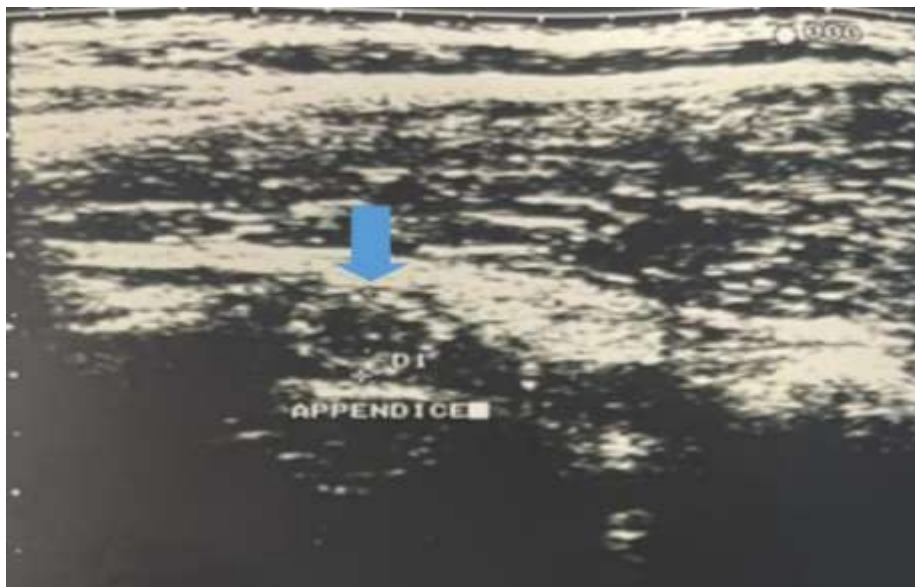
ultrasound image of an enlarged appendix (blue arrow)
